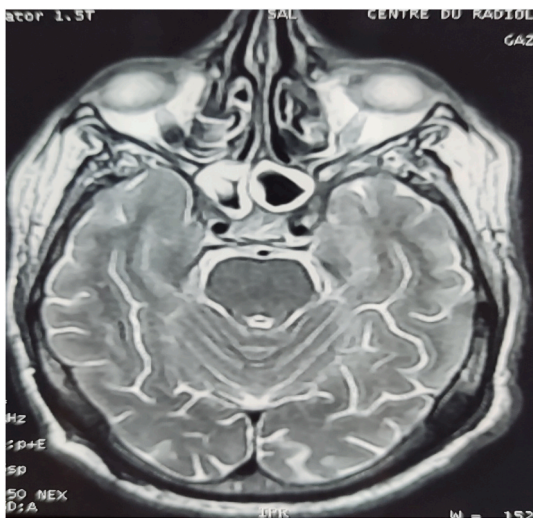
An encephalic magnetic resonance imaging without any abnormalities.
